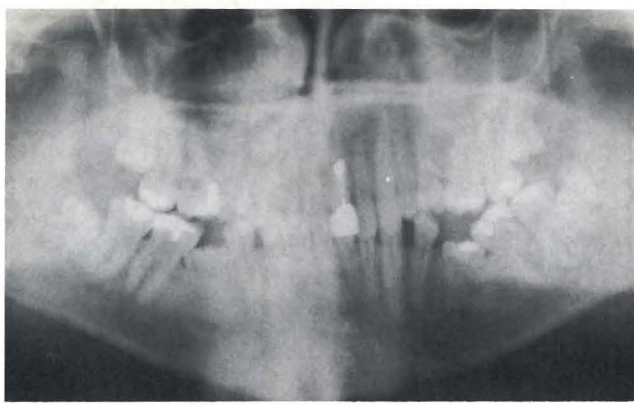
Orthopantomogram of a fourteen-year-old girl with secondary retention of both second primary mandibular molars without a successor. These molars were removed, because of tilting of the neighboring teeth and root resorption of the retained molar.
